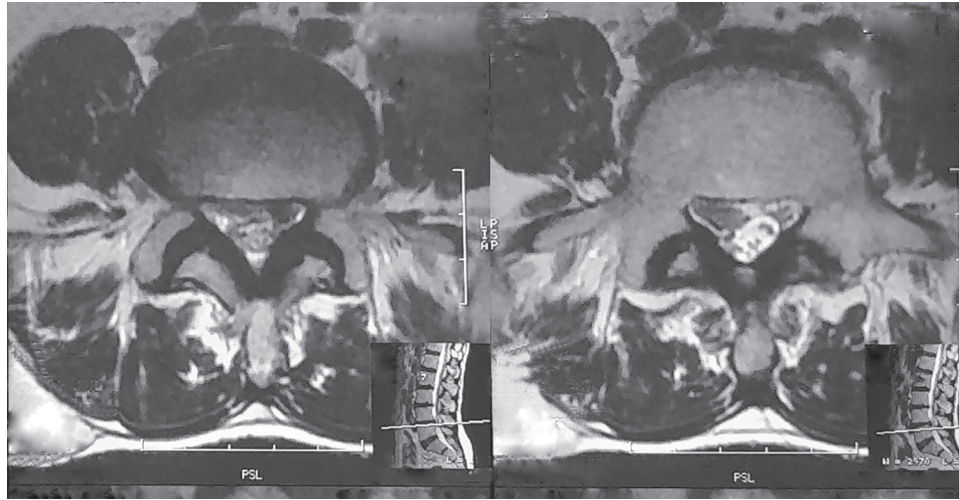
Magnetic resonance imaging showing herniated intervertebral disk: transverse view
